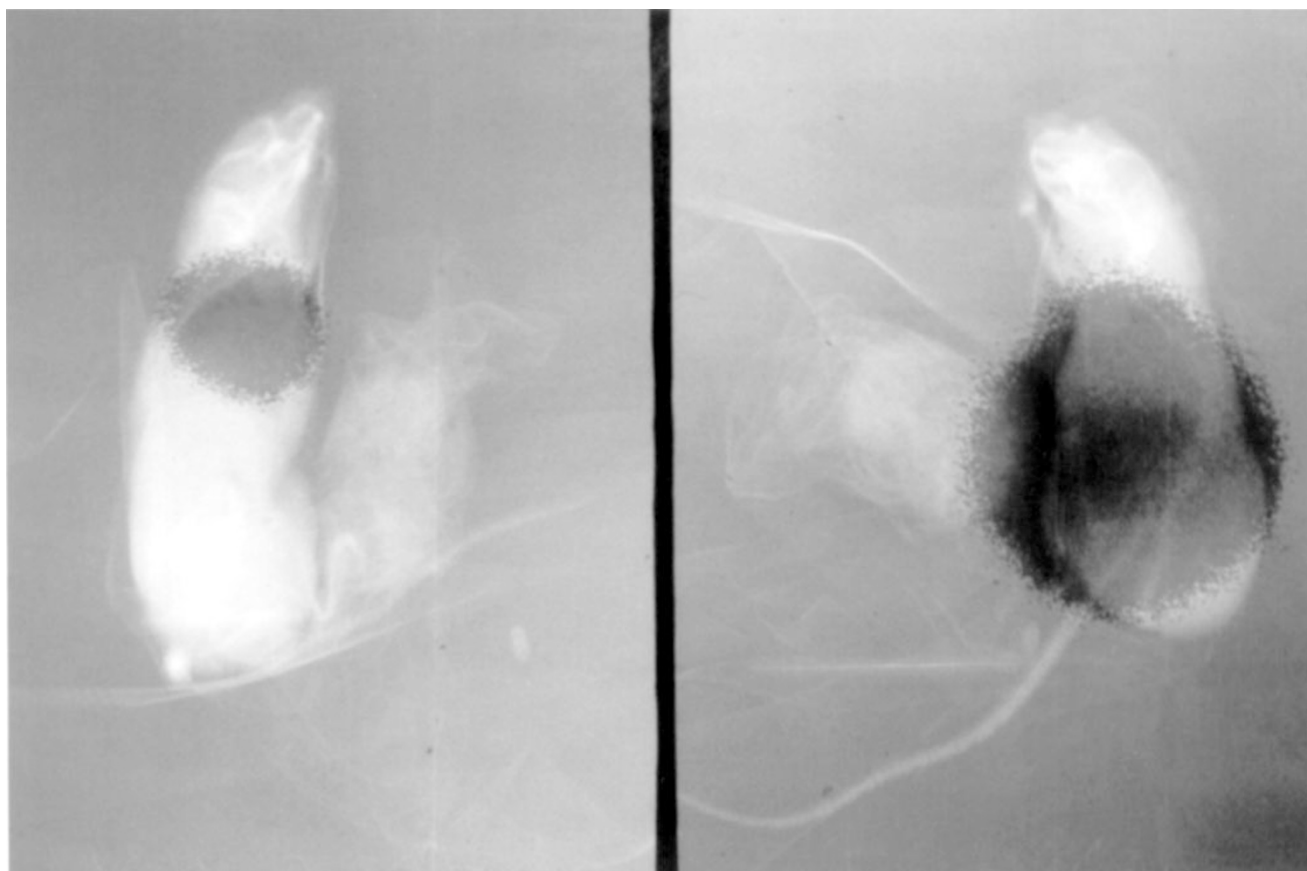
(A) Scintigraphs and radiographs were performed in register to compare relative radioligand uptake in the liver (normal route of excretion). The SKNSH tumour (sst 2-negative) shows intense uptake of a radiolabelled sst 2-preferring somatostatin analogue. (B) Scintigraphs and radiographs were performed in register to compare relative radioligand uptake in the tumour. The SKNSH tumour (sst 2-negative) shows intense uptake of a radiolabelled sst 2-preferring somatostatin analogue
